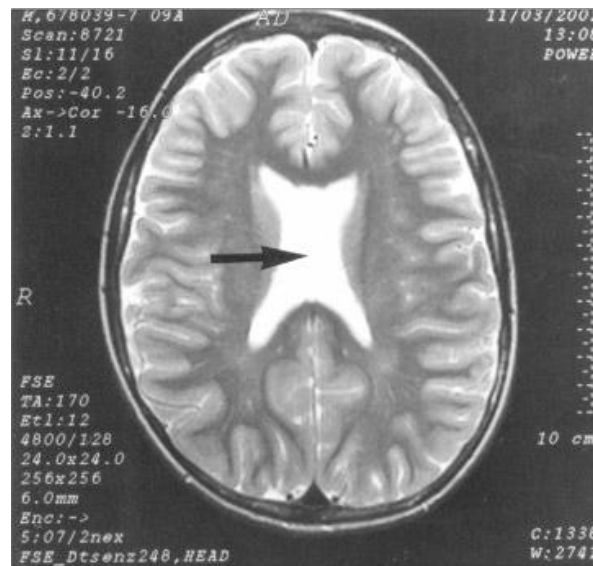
Axial magnetic resonance imaging of the brain revealing absence of the septum pellucidum
